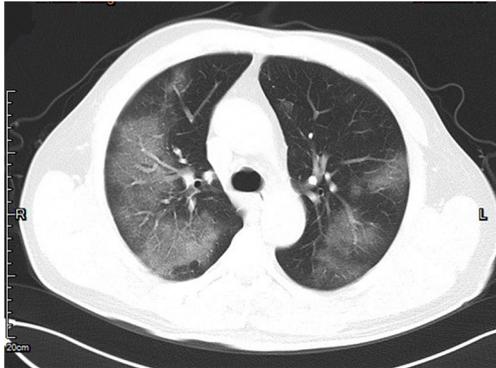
Bilateral lung involvement in a 50-year-old male diagnosed with COVID-19. An axial CT image shows multiple patchy areas of pure ground glass opacities.
